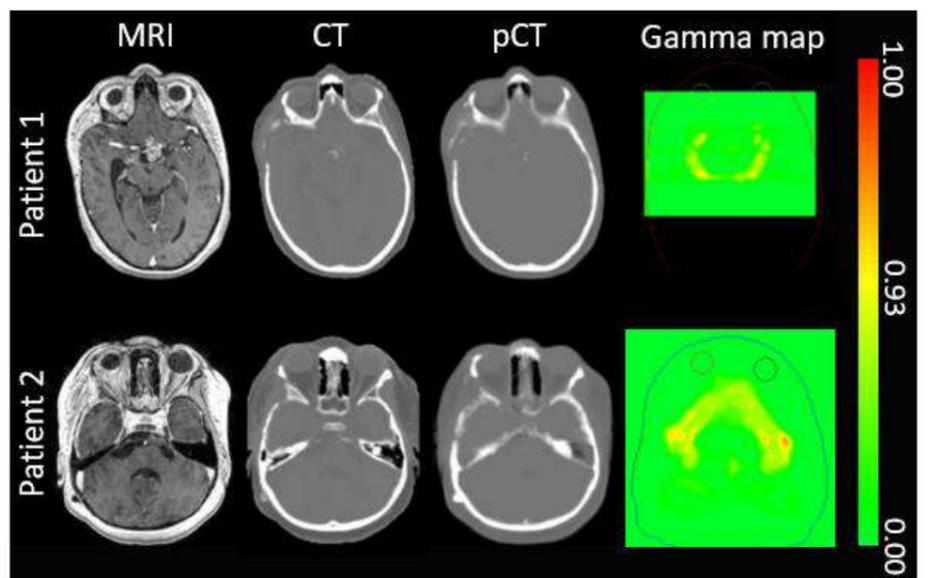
T1-Gd MRI, CT, pCT and gamma maps for the 3%/3mm criterion presented for Patient 1 (17 years old, 6 beams-based treatment, pass rate = 99.69%) and Patient 2 (6 years old, 6 beams-based treatment, pass rate = 99.82%). To improve visibility, external and eye contours are displayed on the gamma maps.
